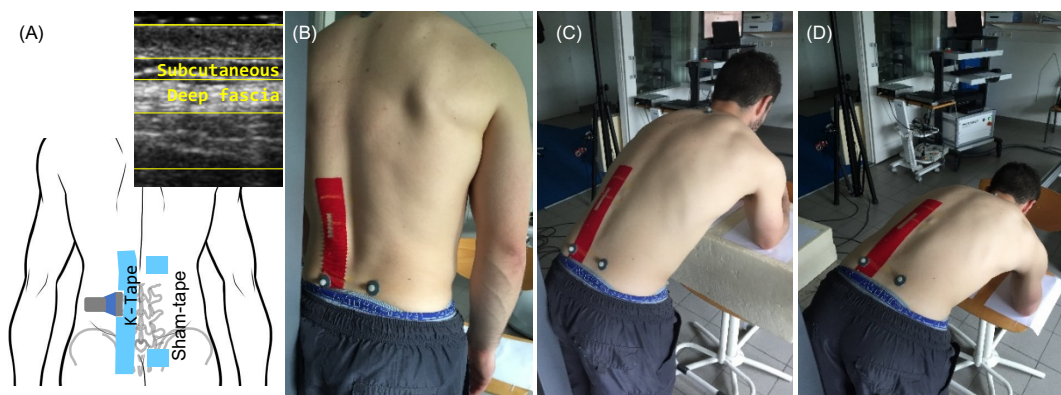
Demonstrations of taping and ultrasound scan positions.
